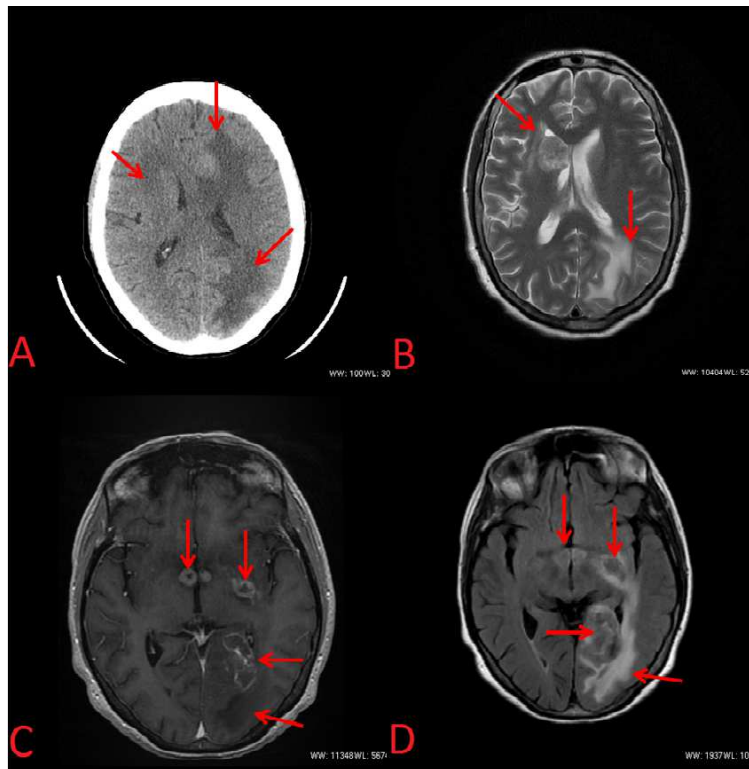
Clinical case of a 38 years old female, diagnosed with both cerebral toxoplasmosis and PML. Picture contains the patient's CT and MRI images:
